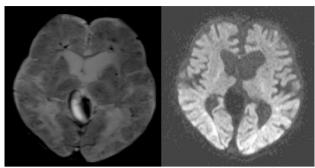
MRI (a) GRE- Showing multiple areas of blooming in sub bilateral subcortical white matter and lentiform nuclei suggestive of calcification. (b) DWI- No restricted diffusion in bilateral white matter
